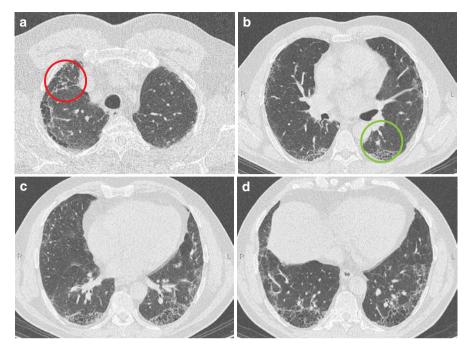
(a) HRCT of the lungs: bilateral and subpleural reticulations, honeycombing in the right upper lobe. (b) HRCT of the lungs: bilateral and subpleural reticulations, honeycombing in both lungs in dorsal parts. (c) HRCT of the lungs: honeycombing dorsally and bilaterally, some reticulations. (d) HRCT of the lungs: reticulations and honeycombing, with maximum changes dorsobasally and bilaterally
